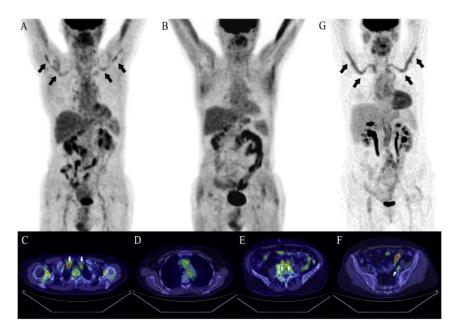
Giant cell arteritis restricted to the limb arteries: An overlooked clinical entity panel of A. coronal reconstructions of FDG-PET study of patient (24)
